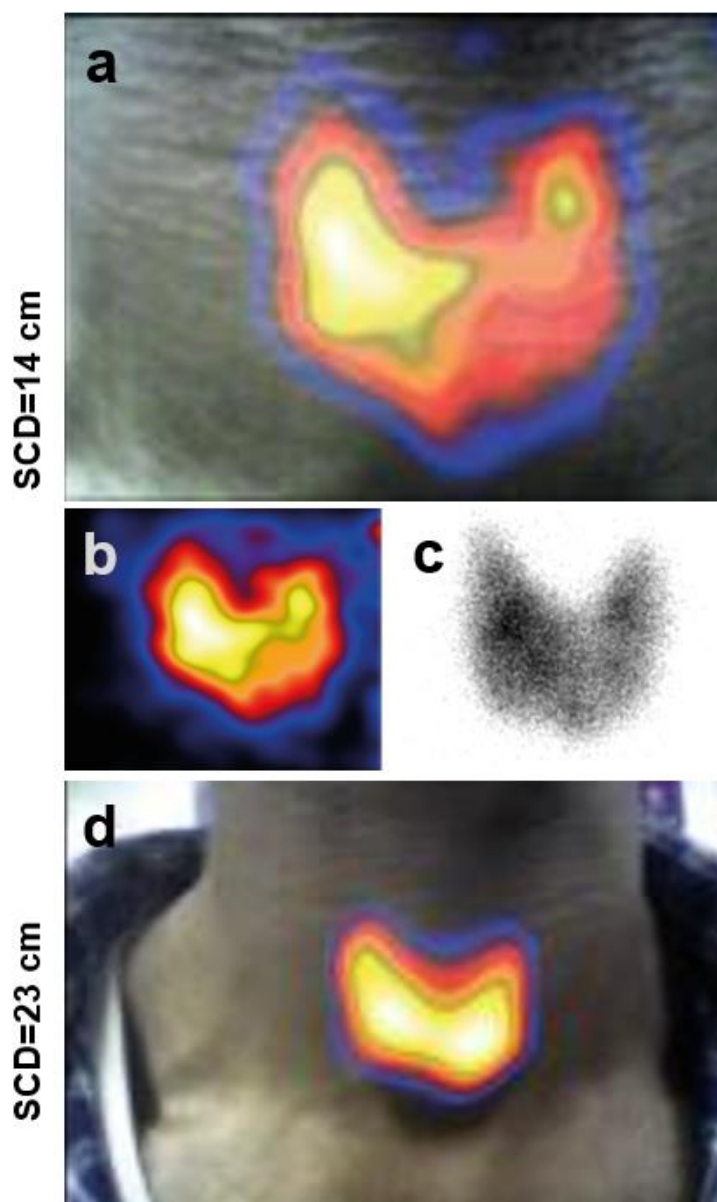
Example thyroid scintigraphy in patient 022, acquired by HGC at 149 minutes post-administration of 18.5 MBq  $^{123}\text{I-NaI}$ , positioned at SCD of 14 cm for a 300 s acquisition time: (a) hybrid (b) gamma image (c) LFOV planar gamma image. (d) Hybrid image of the same patient acquired by HGC positioned at an SCD of 23 cm, 142 minutes post-administration of the radiotracer.
